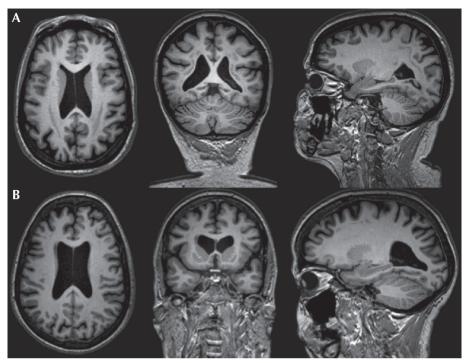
(A) Patient 1 brain MRI (T1 MPR 3D) shows SBH of the temporal, occipital and parietal lobes. (B) Patient 2 brain MRI (T1 MPR 3D) shows subtle SBH of the frontal lobes bilaterally.
